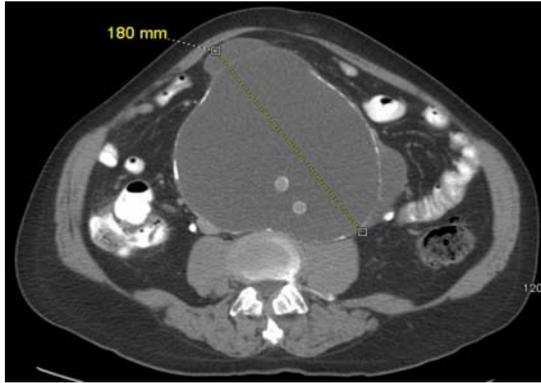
Shows recent axial CT demonstrating rapid increase in size of AAA.
